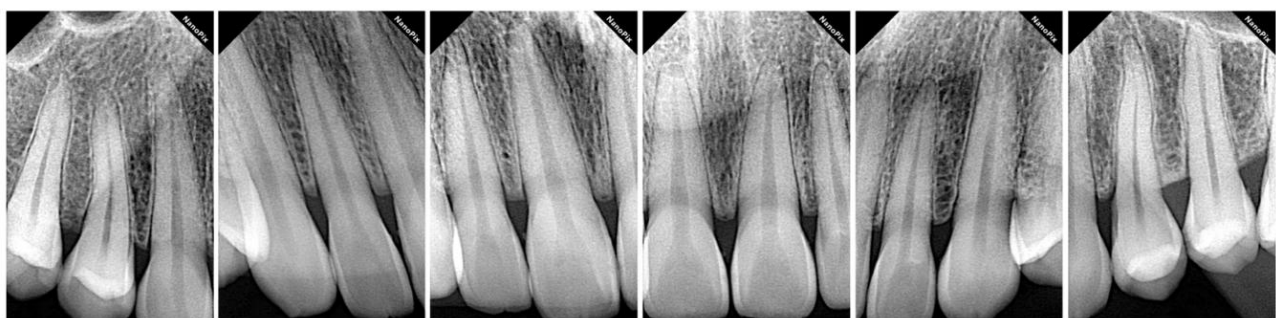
Radiograph examination
